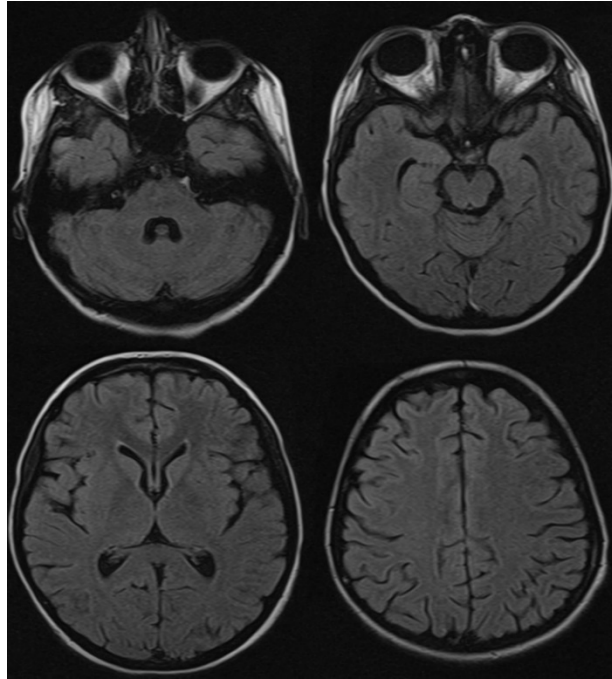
MRI (FLAIR)axial view of our patient’s brain at multiple levels showing no obvious pathology.
